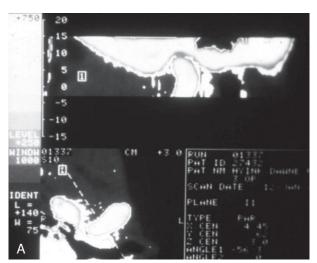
More sophisticated techniques enable the generation of computer-assisted images of clinician-determined cross-sections. (A) A computed tomographic (CT) scan. (B) A magnetic resonance image showing the soft tissue in greater detail. (Courtesy Dr. J. Petrie.)
